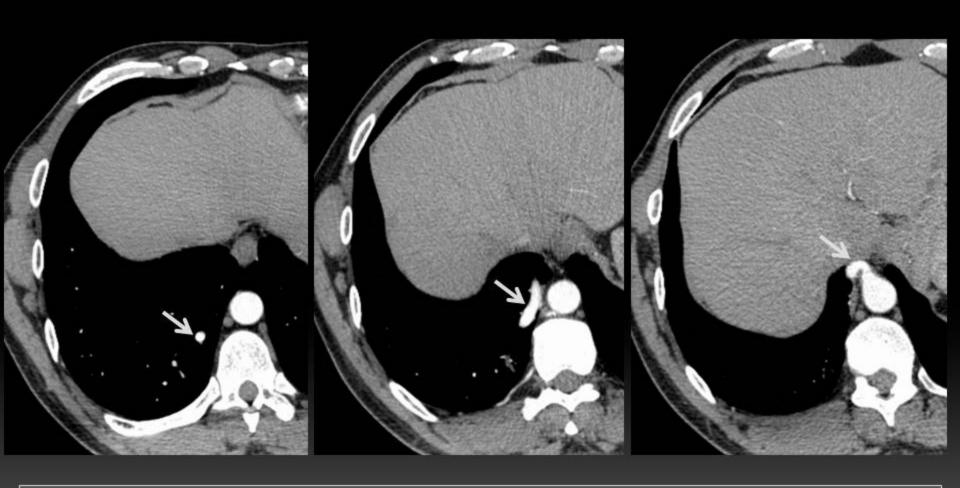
After iv contrast, CT reveals that the tubular structure (arrows) is an artery with abdominal aortic origin and that supplies the abnormal hypoattenuated area of lung. This is compatible with intralobar sequestration.
